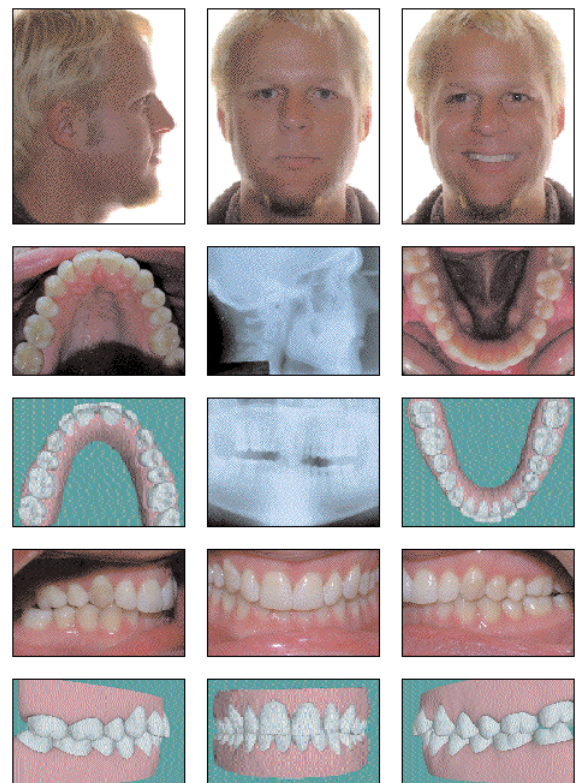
Final appearance of the dentition after Invisalign treatment. Note the well-aligned marginal ridges. The panoramic radiograph shows the parallel roots at the extraction site. The middles are now coincident; the crowding and deep bite have also been corrected.
